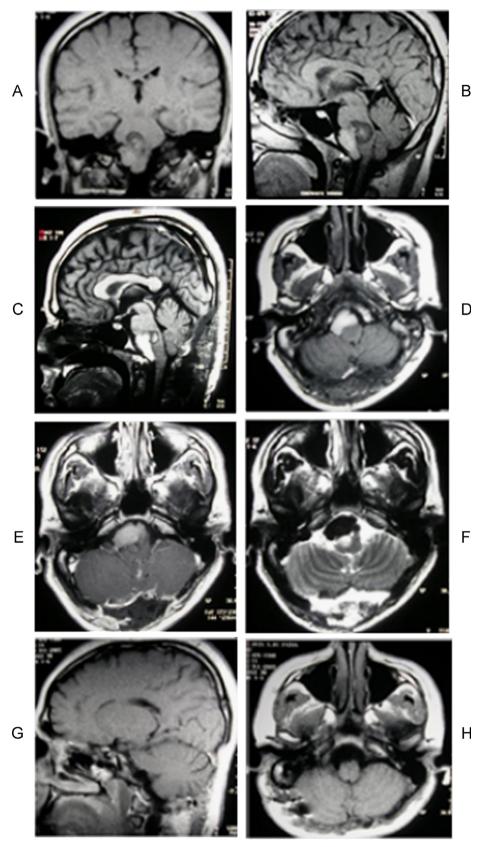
Magnetic resonance image (MRI) showing the different points of the lesion. A—Coronal FLAIR showing brainstem lesion; B—sagittal T11WI showing hypointense lesions; C—sagittal post-gadolinium T1WI showing gadolinium enhancement; D and E—axial post-gadolinium T1WI showing gadolinium enhancement; F—axial T2-WI showing hypointense lesions and edema; G and H—T1 MRI showing improves of the lesion after treatment.
